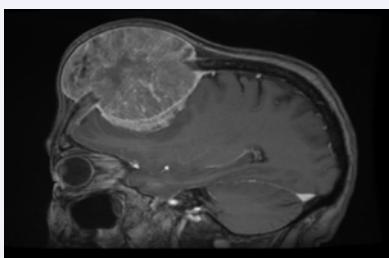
Sagittal brain MRI.
